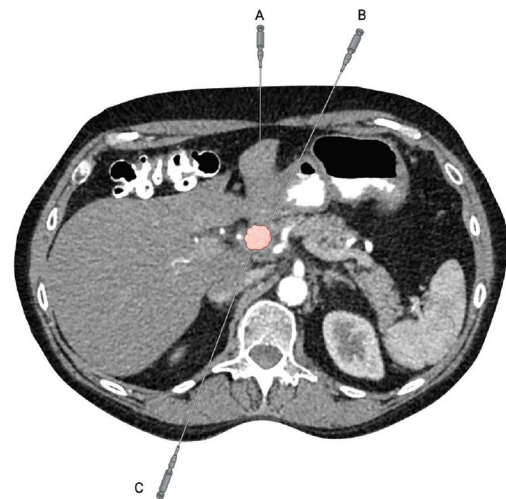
Axial CT of the upper abdomen showing a pancreatic head mass and various transorgan fine-needle aspiration approaches. A indicates the anterior transhepatic approach, B indicates the anterior transgastric approach, and C indicates the posterior approach. (Created with BioRender.com.)
